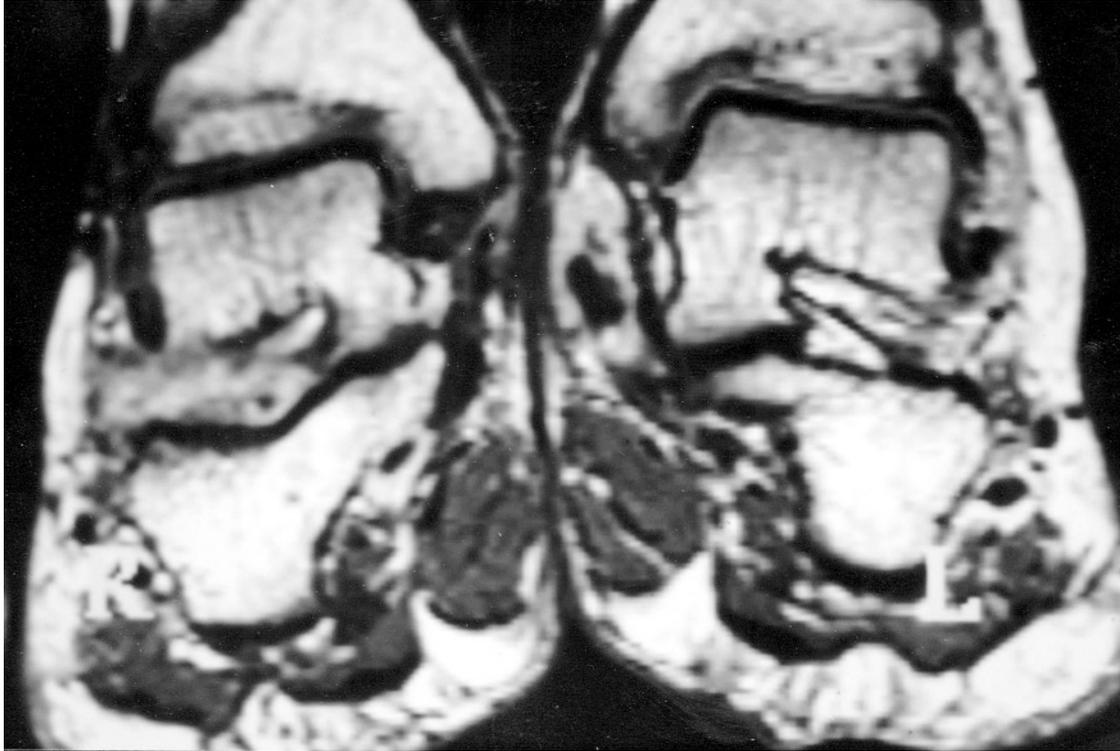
MRI after gadolinium injection. Right foot: enhancement of pannus in sinus tarsi and ruptured interosseous ligament.
